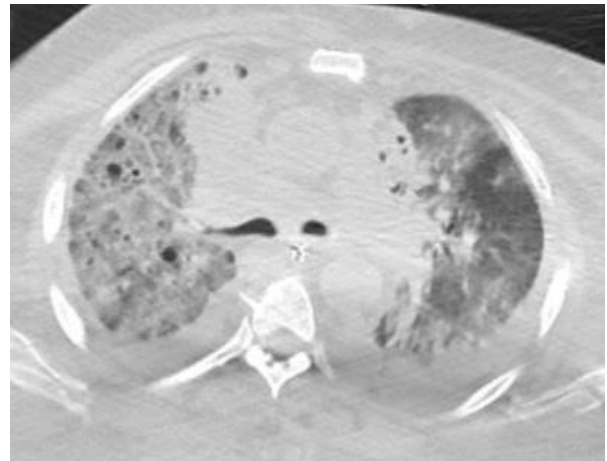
CT chest shows ground glass and alveolar extensive infiltration and cavitary nodules particularly in upper lobes.
